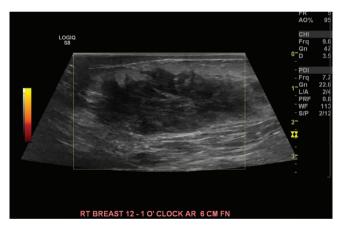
A $4.4 \times 1.9 \times 3.7$ cm indistinct area of mixed echogenicity in the right breast at 1:00, 6 cm from the nipple, lacking significant flow on power doppler in the right breast, corresponding to partially persistent asymmetry on mammogram
